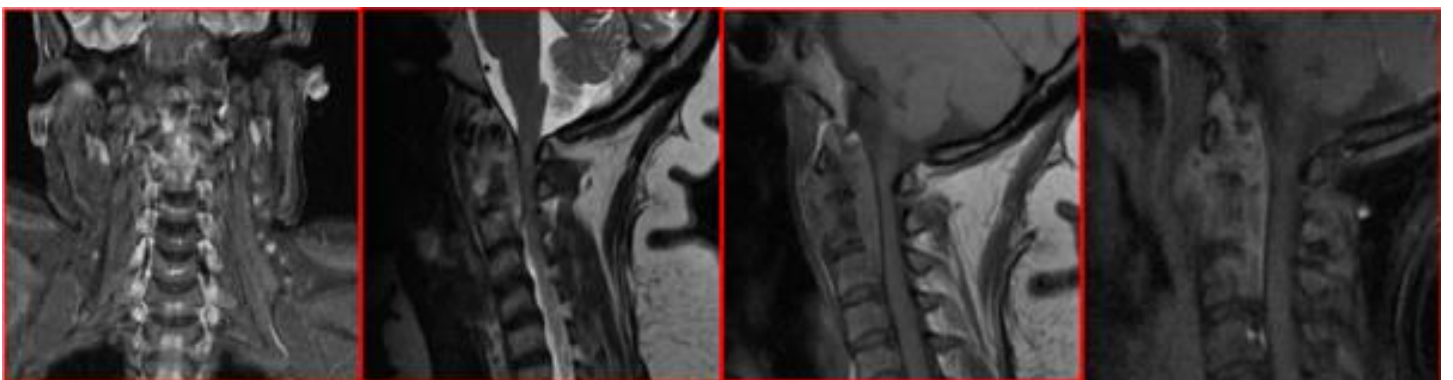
MRI of the Cervical spine showing Ill-defined moderately T2/T2 STIR non-homogenously hyperintense signals noted involving odontoid process and body of C2 vertebra, postero-superior aspect of C3 vertebra with adjacent epidural collection from CV junction to mid C3 level causing mild compression of the spinal cord.
